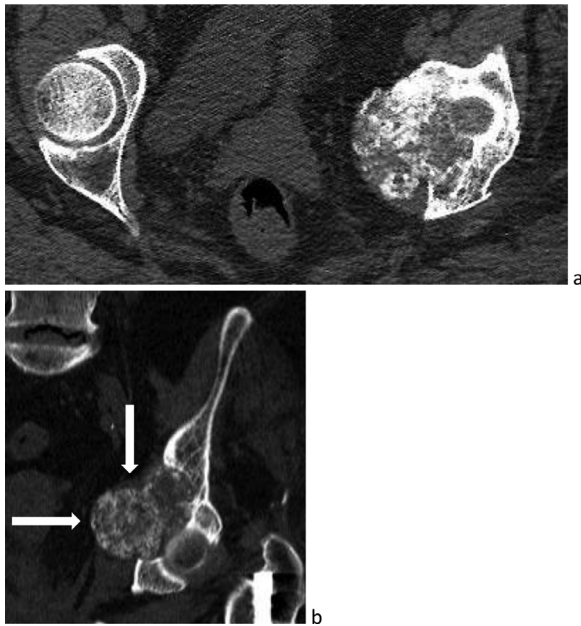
Axial (A) and coronal (B) images in soft tissue and bone window, respectively, from a noncontrast CT scan of the pelvis at the level of the acetabulum from 2022, shortly after the patient was found to have biopsy-proven recurrent disease.
